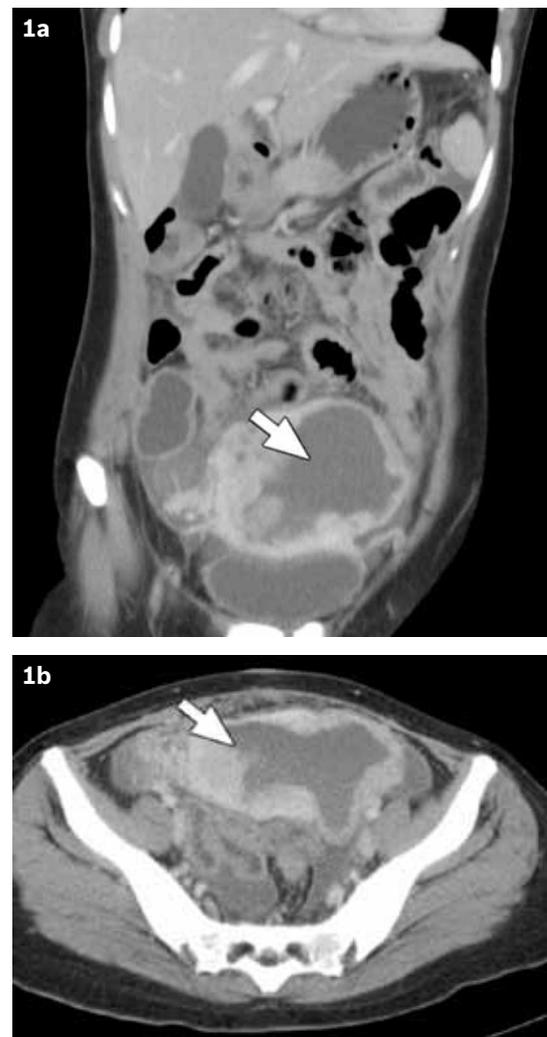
(a) Axial and (b) coronal CT images show a large haematometra (arrowhead) with a thin uterine fundus at first presentation.
